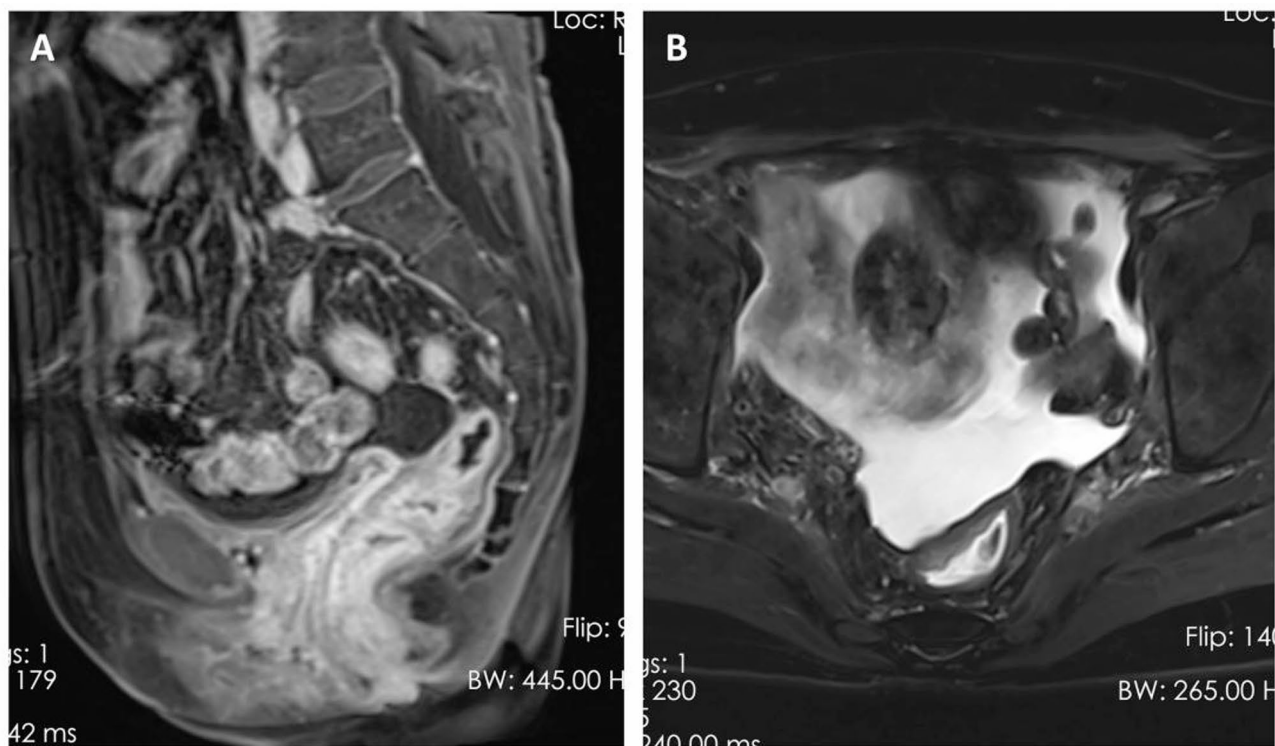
Postoperative magnetic resonance imaging. (A) Postoperative sagittal T1 enhancement. (B) Postoperative axial fat-suppressed T2-weighted imaging
